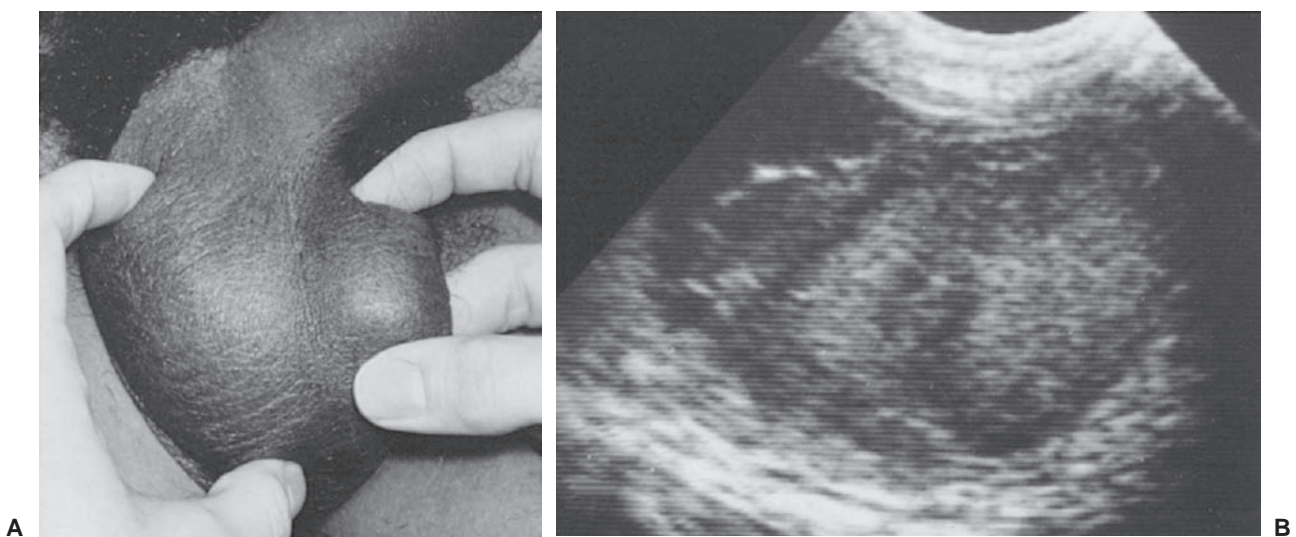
Rupture of testis. A: Testicular swelling and tenderness following kick to scrotum. B: Ultrasound examination of testis—central linear sonolucent area reflects site of testicular rupture. Surgical repair resulted in a well-preserved gonad.
